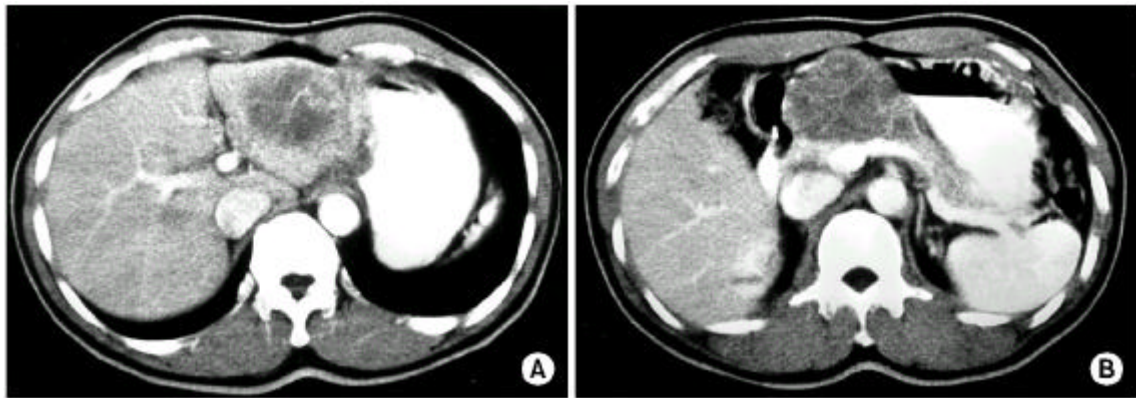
(A) In this abdominal CT scan, a heterogeneously low density mass is seen on the left lateral segment of the liver. (B) The mass is exophytic and displaces the pancreas downwards.
